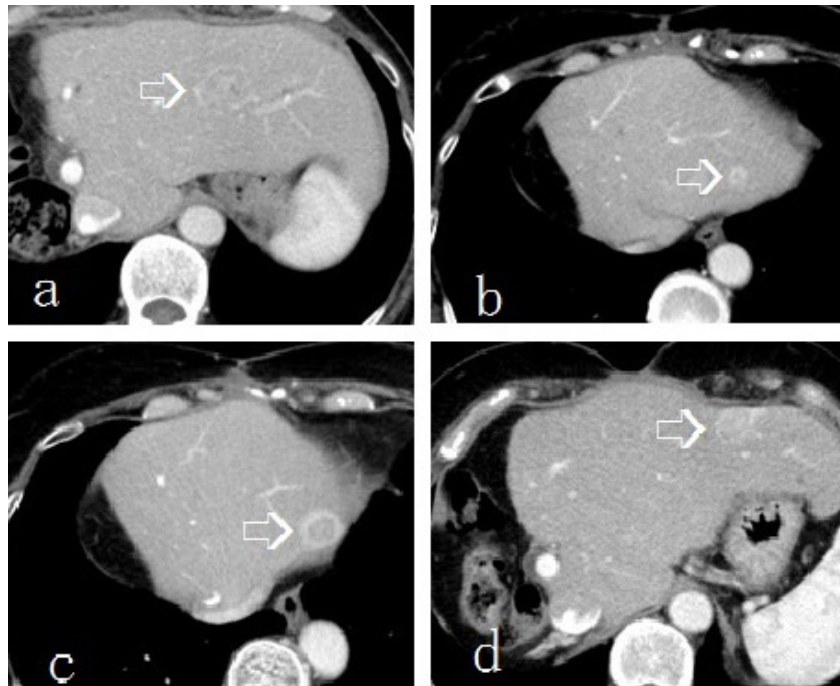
Abdominal enhanced computed tomography of the recurrent tumor in the remnant liver
